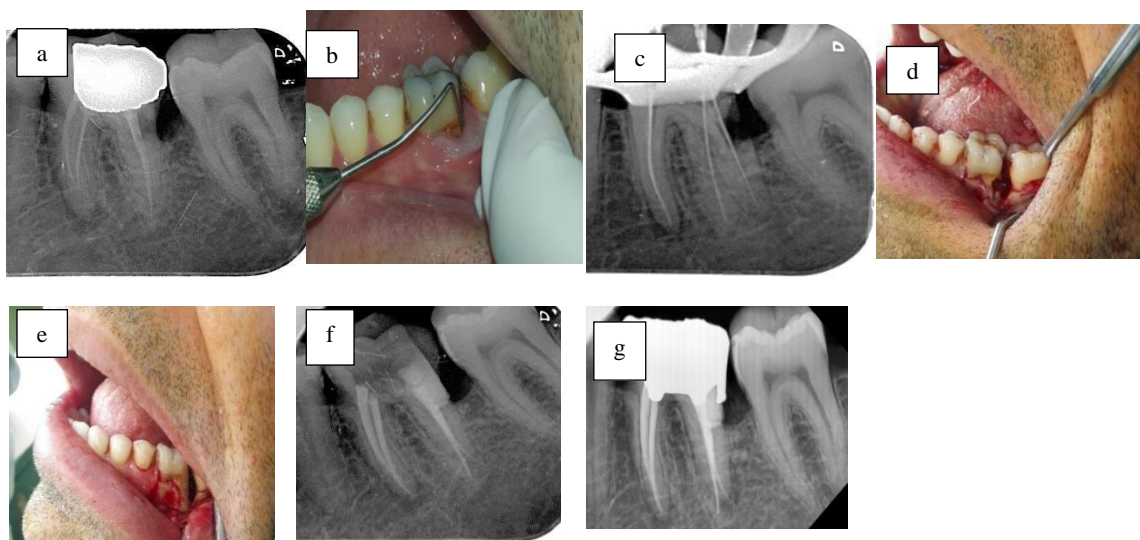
(a) Preoperative radiograph of teeth #19; (b) clinical examination and pocket depth of 6 mm at proximal distal root surface; (c) non-surgical endodontic retreatment of tooth #19; (d) surgical exposure of the resorptive area; (e) restoration of the defect with glass-ionomer cement; (f) post-operative radiograph; (g) follow-up radiograph 3 month after operation
